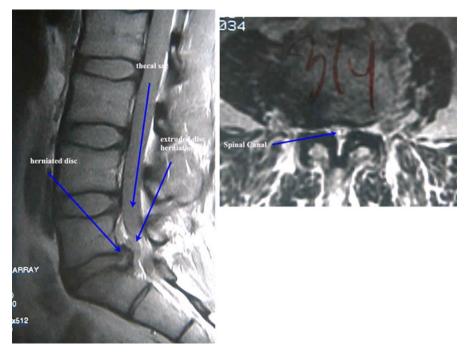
MRI images (T1 weighted) with abnormal findings: Left, sagittal view showing a disc herniation at L5-S1 with compression of the nerve roots. Right, T2 weighted Axial MRI view in another patient showing severe central and lateral recess spinal stenosis at the level L3-4.
